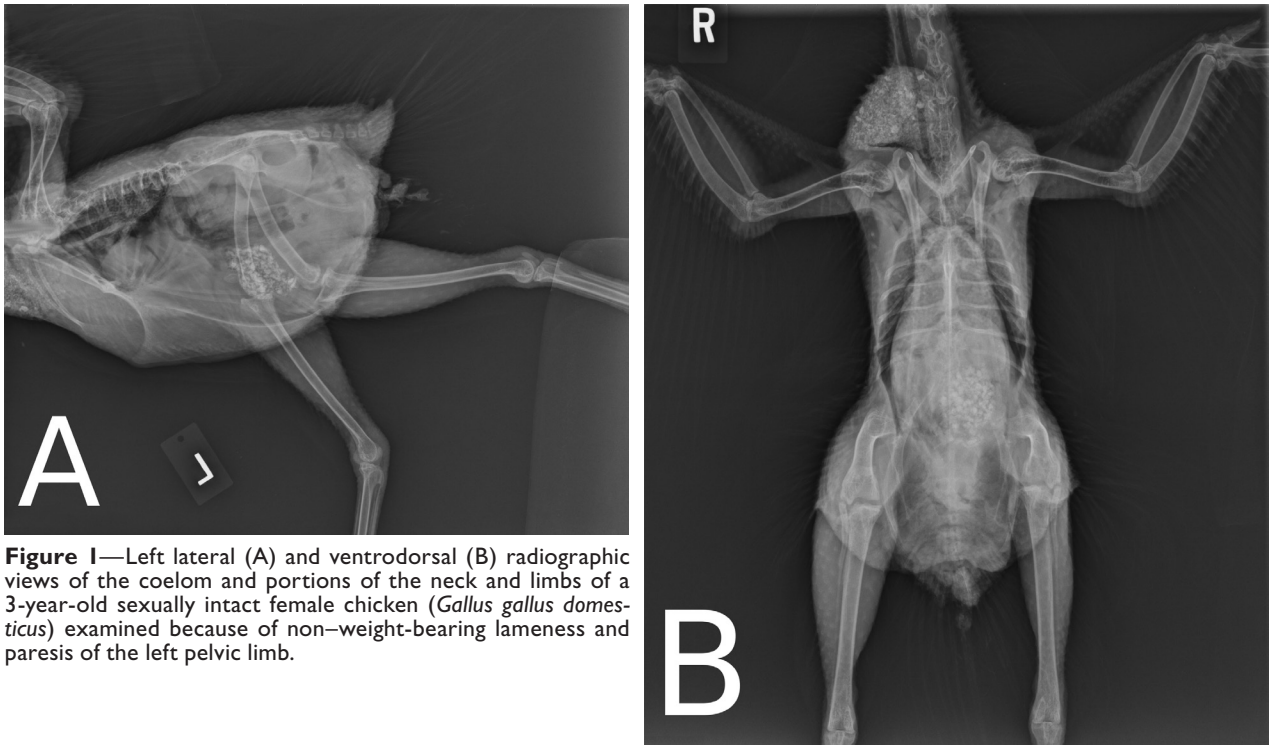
Left lateral (A) and ventrodorsal (B) radiographic views of the coelom and portions of the neck and limbs of a 3-year-old sexually intact female chicken (*Gallus gallus domesticus*) examined because of non-weight-bearing lameness and paresis of the left pelvic limb.
